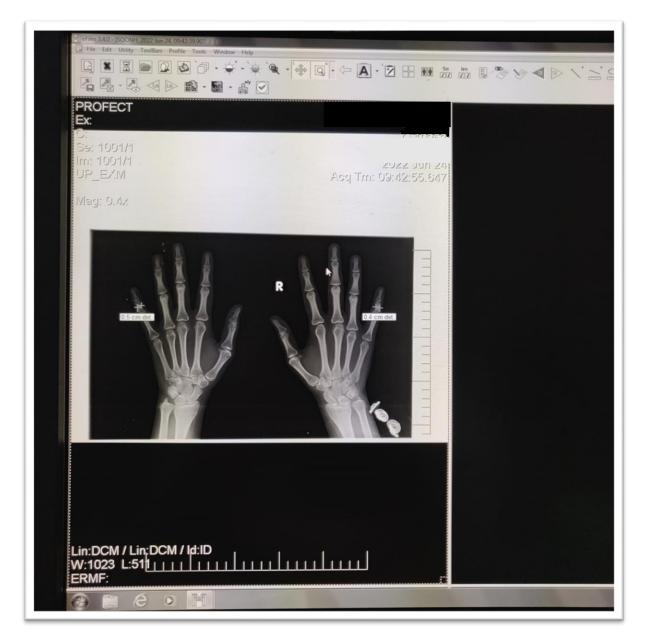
X-ray image of both the hands of the subject. The thickness of the middle phalanges of 5th digits have been marked and measured at their visible narrowest thickness.
